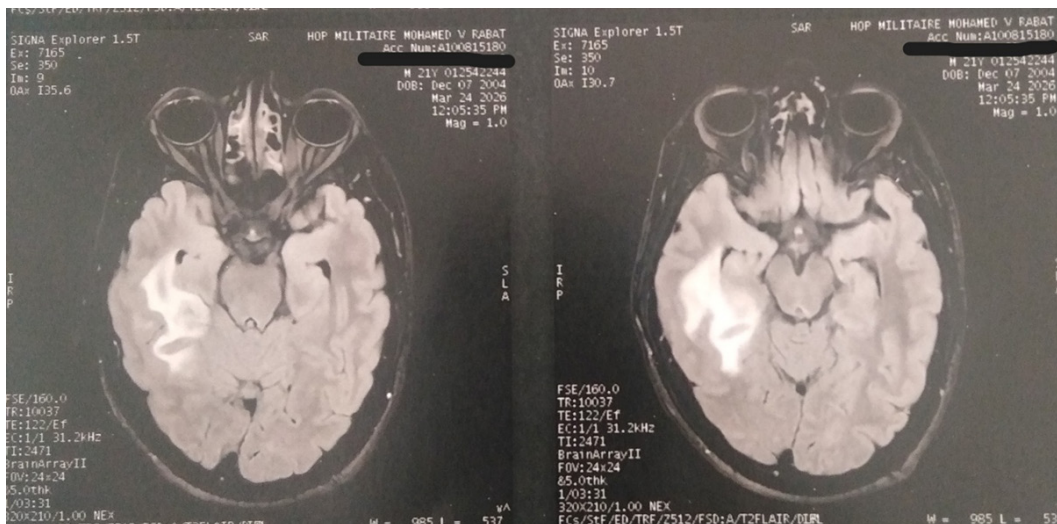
Brain MRI showing perilesional edema with high signal intensity.
